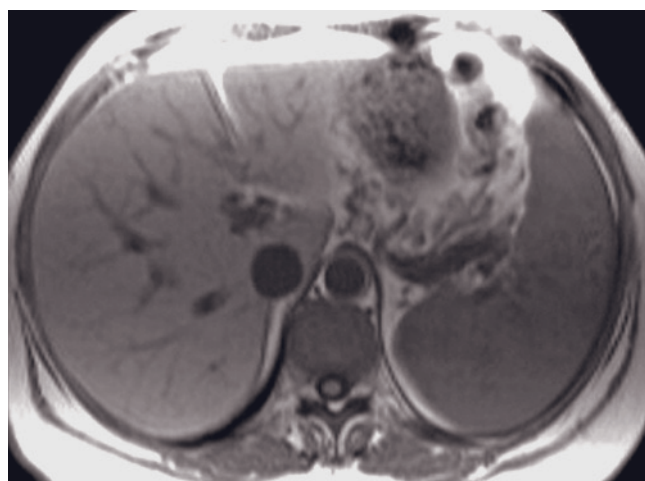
Sarcoidosis. T1-weighted SGE (a), T2-weighted fat-suppressed spin-echo (b), and immediate (c) and 10-min (d) postgadolinium T1-weighted SGE images. Multiple sarcoidosis granulomas, smaller than 1 cm, are present in the spleen. Lesions are mildly hypointense to isointense on T1-weighted images (a), moderately hypointense on T2-weighted images (b), and hypointense on immediate postgadolinium images (c), gradually enhancing to near isointensity on delayed postgadolinium images (d). Hypointensity on T2-weighted images distinguishes these lesions from those of infectious etiologies. (Reproduced with permission from Warshauer DM, Semelka RC, Ascher SM: Nodular sarcoidosis of the liver and spleen: appearance on MR images. *J Magn Reson Imaging* 4: 553-557, 1994.) T1-weighted SGE (e), T2-weighted single-shot echo-train spin-echo (f), immediate postgadolinium
